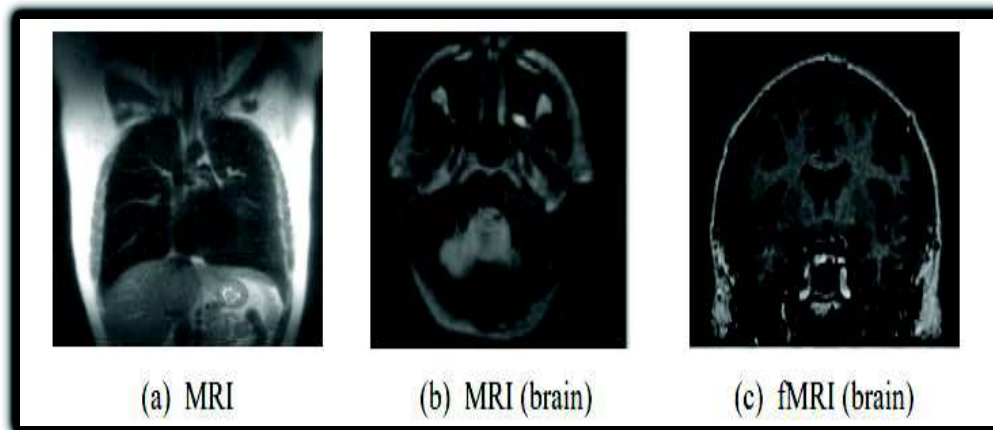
Example MRI images
